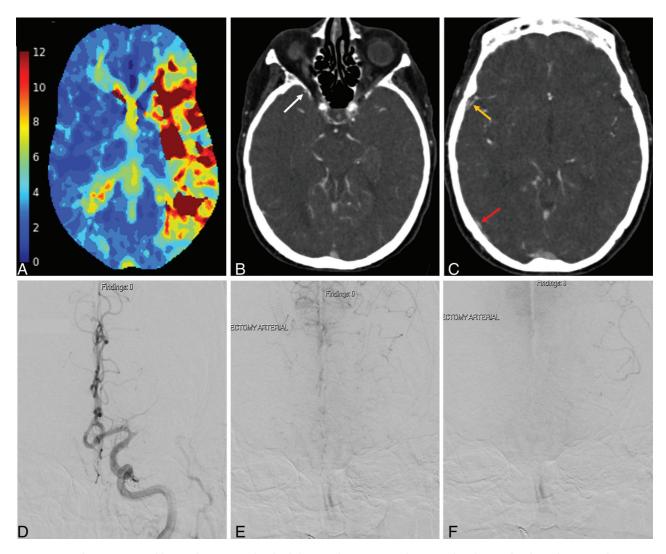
Images from a 74-year-old man who presented with a left M1 occlusion acute ischemic stroke. The RapidAl-derived Tmax perfusion map (A), axial CTA at different levels (B-C), and preintervention DSA images in the anterior-posterior view during the early arterial phase (D), parenchymal (E) and later venous (F) phases are shown. There is delayed contrast transit in the left MCA territory on the Tmax perfusion map (A). Images from the contralateral unaffected hemisphere (B-C) demonstrate opacification of the sphenoparietal sinus (B, white arrow), superficial middle cerebral vein (C, yellow arrow), and vein of Labbé (C, red arrow). Whereas, on the affected hemisphere there is no opacification of sphenoparietal sinus (B), superficial middle cerebral vein (C), and vein of Labbé (C), resulting in a COVES score of 0. The preinterventional DSA shows poor leptomeningeal retrograde filling of the initial antegrade capillary blush deficit (target downstream territory; ASITN grade 1).
